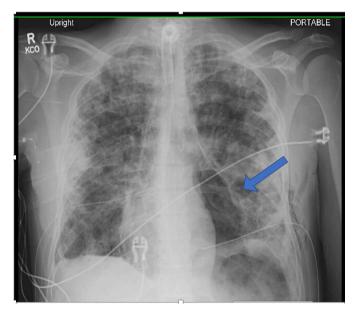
Chest X-ray with large volume pneumopericardium, cardiac compression, and mediastinal shift consistent with tension pneumopericardium. Single arrow: Air within pericardial sac.
